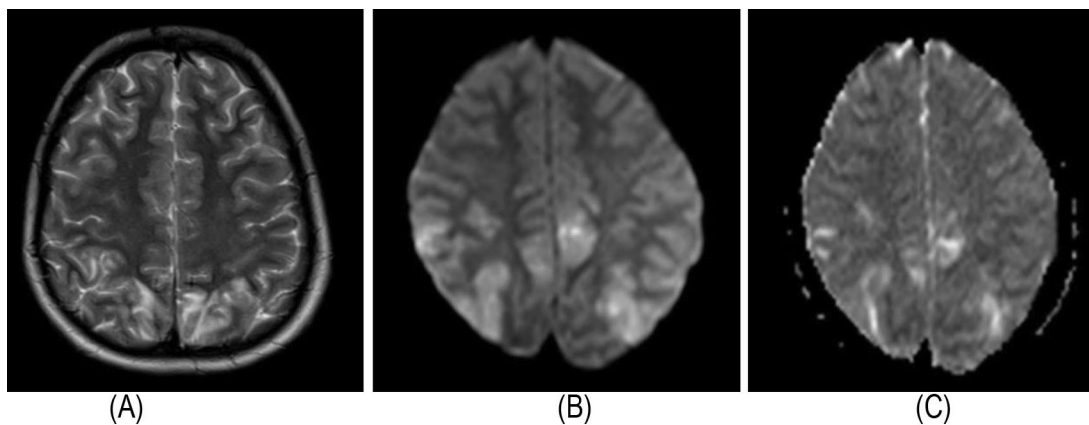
Axial T2W image of posterior reversible encephalopathy syndrome showing hyperintensity on T2W image in bilateral parieto-occipital region (A), showing bright signal on DWI (B) & on ADC (C)
